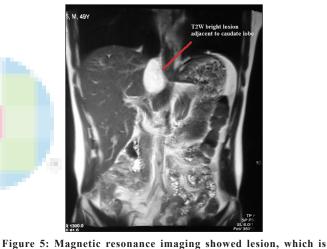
Magnetic resonance imaging showed lesion, which is T1-weighted low signal located adjacent to caudate lobe of liver
